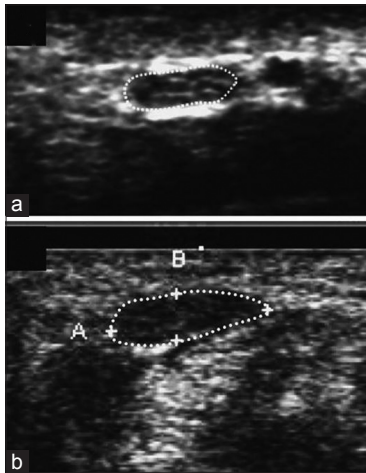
(a) Transverse view of sonogram of the median nerve at the carpal tunnel inlet in a healthy subject. The outer margin of the median nerve is surrounded by a dotted line. (b) Transverse view of sonogram of the median nerve at the carpal tunnel inlet in a subject with carpal tunnel syndrome. The nerve is relatively hypoechoogenic
